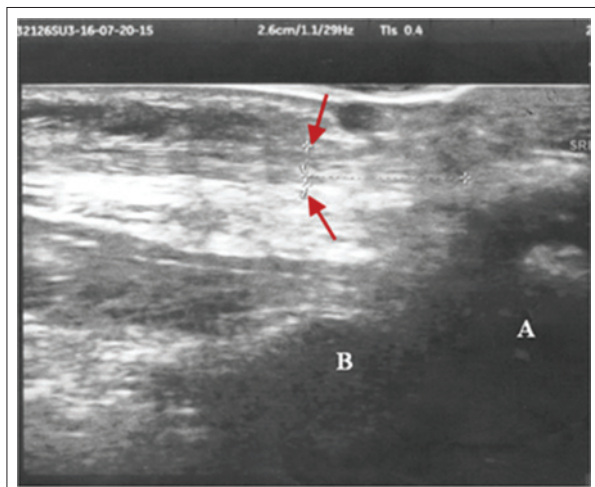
Ultrasound scan before tenotomy it shows homogeneously echoic fibrillar structures arrow. (A) Osseous portion of calcaneum, (B) Tibia.
